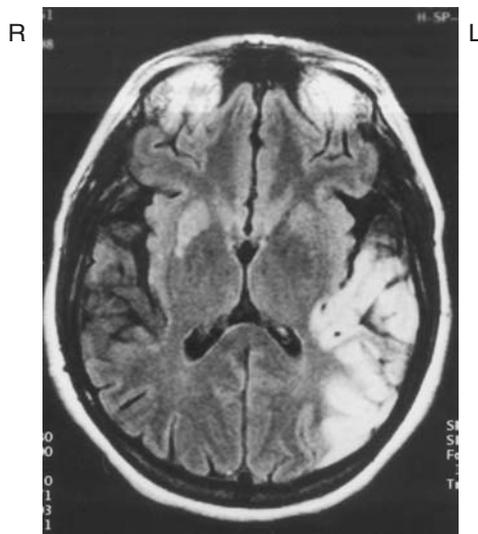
A transverse T2 magnetic resonance image showing an enhanced signal in the area of the left primary auditory cortex (Heschl's gyrus and planum temporale) with the lesion extending into the posterior parietal lobe. The area of infarct represents distribution of the middle cerebral artery.
